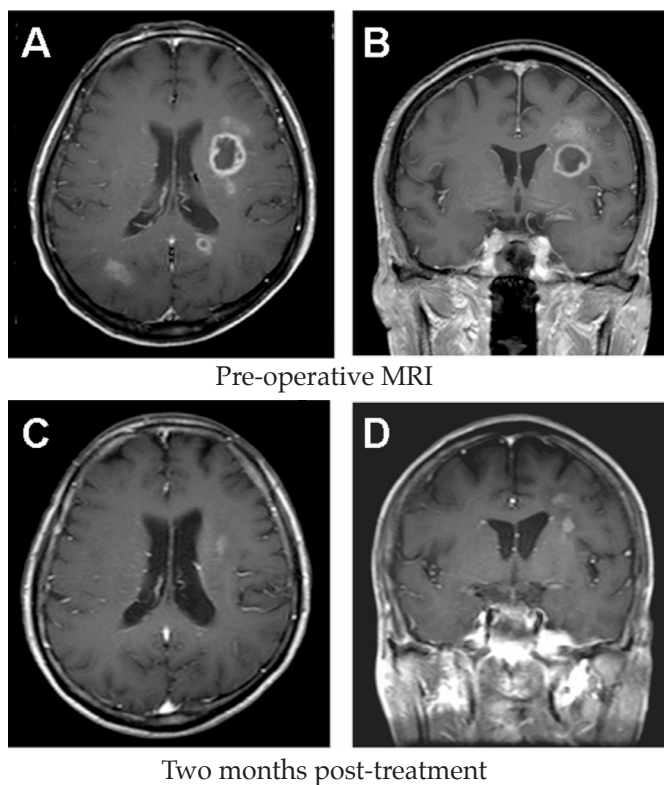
MRI shows multiple rim enhancing abscesses with perilesional vasogenic edema (1A: T1 axial view, 1B: T1 coronal view). Two months later the MRI shows resolution of the brain abscesses (1C: T1 axial view, 1D: T1 coronal view).
